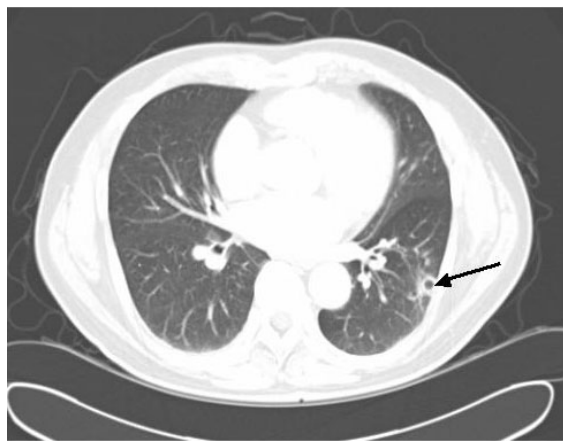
Two weeks follow-up chest CT depicted markedly diminished size of the nodule with thinning of the cavity walls (arrow).
